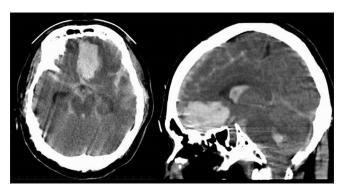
Preoperative computed tomography. CT scans demonstrating a subarachnoid hemorrhage (CT) on admission with a large intracerebral hematoma in the left frontal lobe
